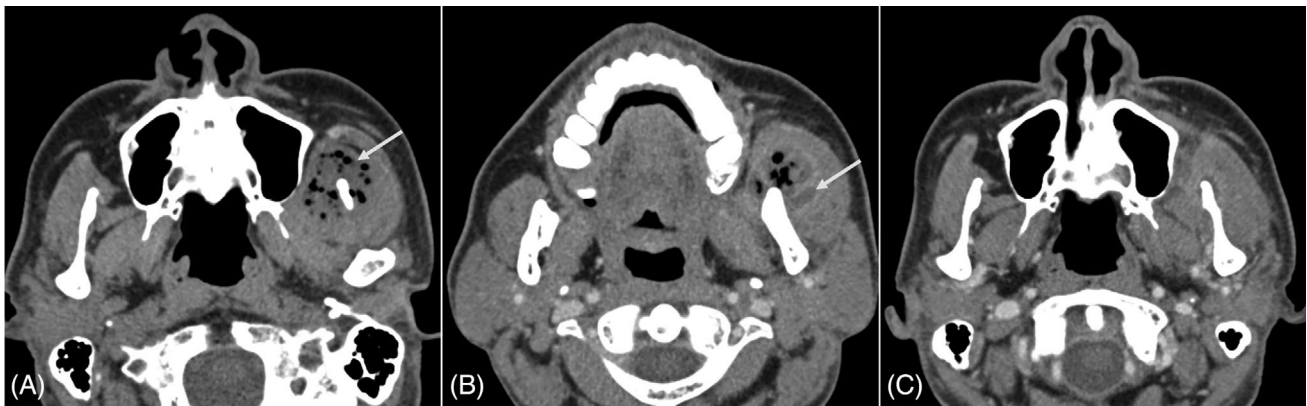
Craniofacial necrotising fasciitis (CNF) in a 58-year-old man because of unknown origin. (A) Axial computed tomography (CT) shows multiple soft-tissue abscess with air bubbles (white arrow), (B) At enhanced phase, axial CT shows polymorphic wall enhancing lesions in the muscle (white arrow), (C). CT image of POD 25, more decreased size of abscess formation in left masseter and temporalis muscle
